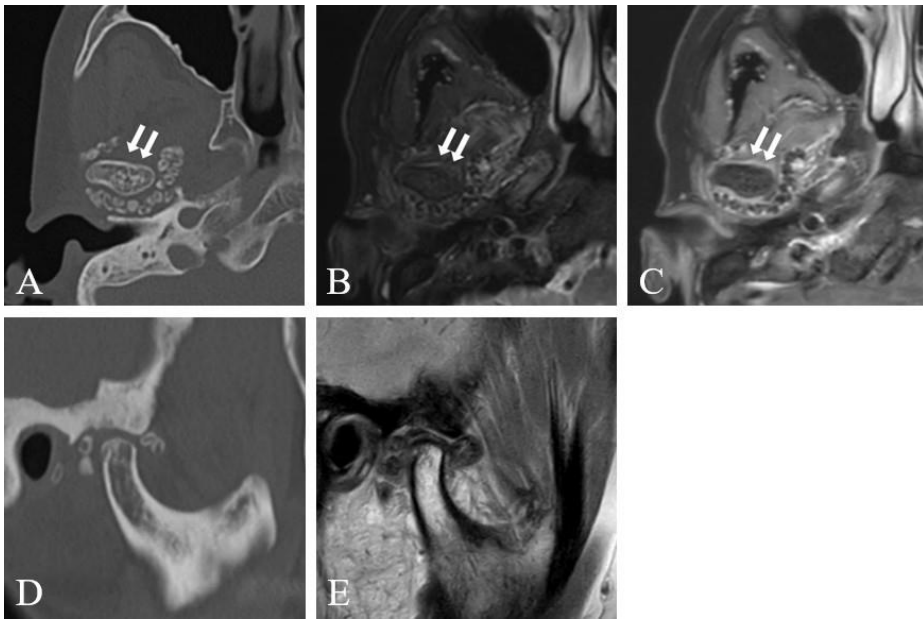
Representative images of synovial chondromatosis of the left TMJ in a 54-year-old woman. (A–C) Axial MDCT, fat-suppressed T2-weighted MR, and contrast-enhanced T1-weighted MR images show that the mass, containing ring-and-arc calcification, does not infiltrate into the tendon of lateral pterygoid muscle, but surrounds the muscle attachment (white arrows). (D and E) Sagittal MDCT and proton density-weighted MR image demonstrate the lesion epicenter of joint space. Note severe sclerosis of the articular eminence/glenoid fossa, but relatively intact bone marrow of the mandibular condyle.
